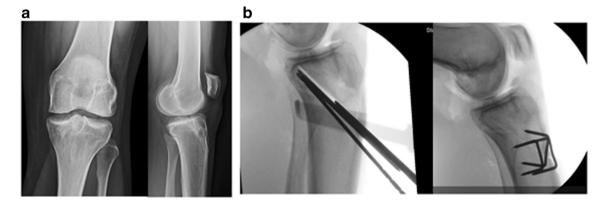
a Pre-operative AP and lateral radiographs of a young adult patient with ACL graft re-tear, medial meniscus deficiency, and increased tibial slope. b Intra-operative fluoroscopy images demonstrating proximal tibial
